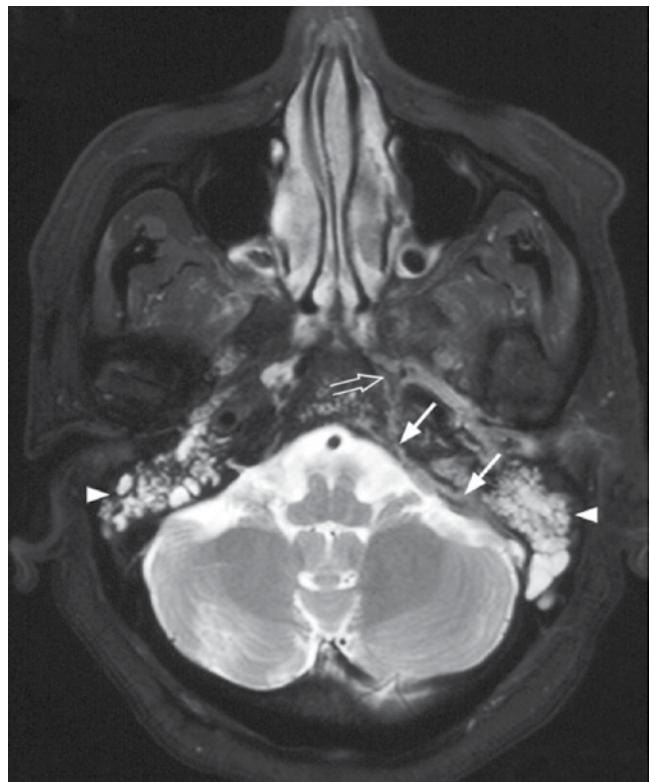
Magnetic resonance imaging (MRI) scan of skull base in a 59-year-old man with a 20-year history of diabetes (with nephropathy), treated with insulin, who developed severe extensive invasive aspergillosis. He presented with headache and vertigo followed by left sixth and seventh nerve palsies. He subsequently developed bilateral sensorineural hearing impairment and blindness secondary to extensive skull base infiltration by the invasive aspergillosis. MRI demonstrated enhancing soft tissue closely related to the left posterolateral wall of the nasopharynx with parapharyngeal, skull base, perineural, and dural infiltration. Biopsy showed inflamed fibrous tissue with degenerated fungal filaments.
